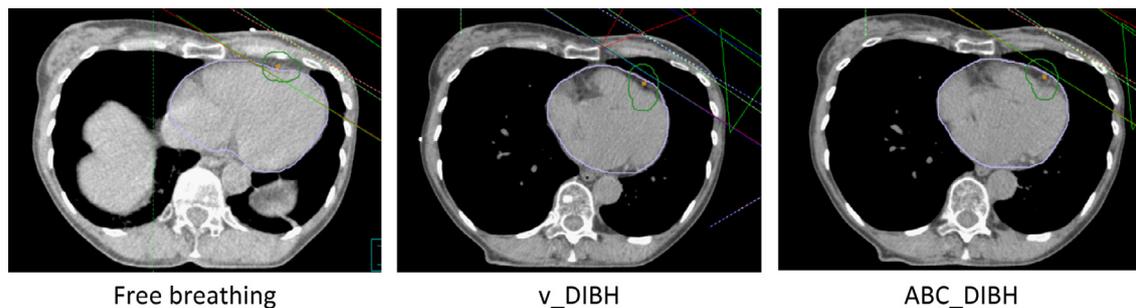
Axial CT slices of one patient taken during free breathing, v_DIBH and ABC_DIBH. Heart, left anterior descending coronary artery (LAD) and LAD with 1 cm margin have been outlined. Key: magenta – heart, orange – LAD, dark green – LAD plus 1 cm margin.
